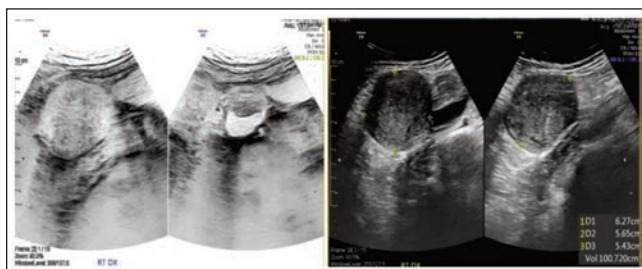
Ultrasound scan of the endometrium cavity with complex fluid.
